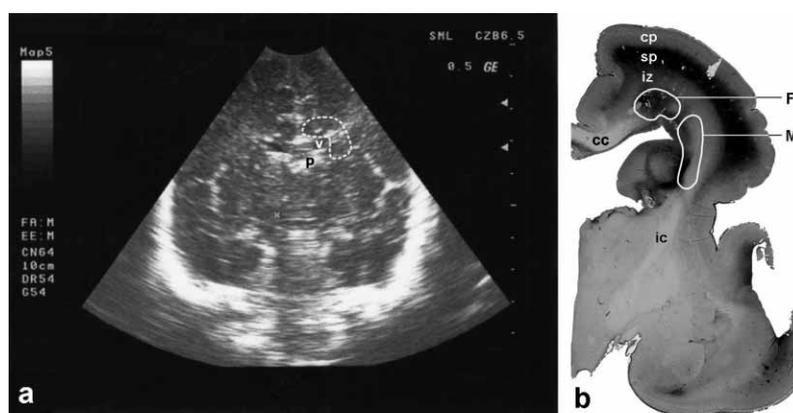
a) Coronal section on an ultrasound image of a 2 month- old infant. The area that encompasses both the frontal and the main crossroads is indicated by the dotted line. v – lateral ventricle; p – plexus choroideus. b) Coronal section through the telencephalon of 20 week-old fetus, as revealed by fibronectin immunocytochemistry. The position of the frontal crossroad, situated dorsally to the anterior horn of the lateral ventricle, and the main crossroad, situated laterally to the lateral ventricle, is indicated. The Zagreb Neuroembryological Collection. cp – cortical plate; sp – subplate; iz – intermediate zone; cc – corpus callosum; ic – internal capsule, F – frontal crossroad, M – main crossroad.
